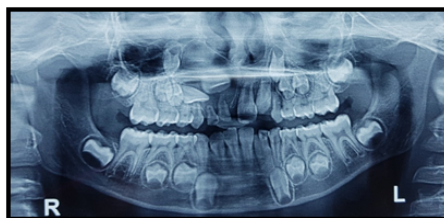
Orthopantomograph revealed unilocular radiolucency on right side extending from mesial aspect of 21 to mesial aspect of 14.
